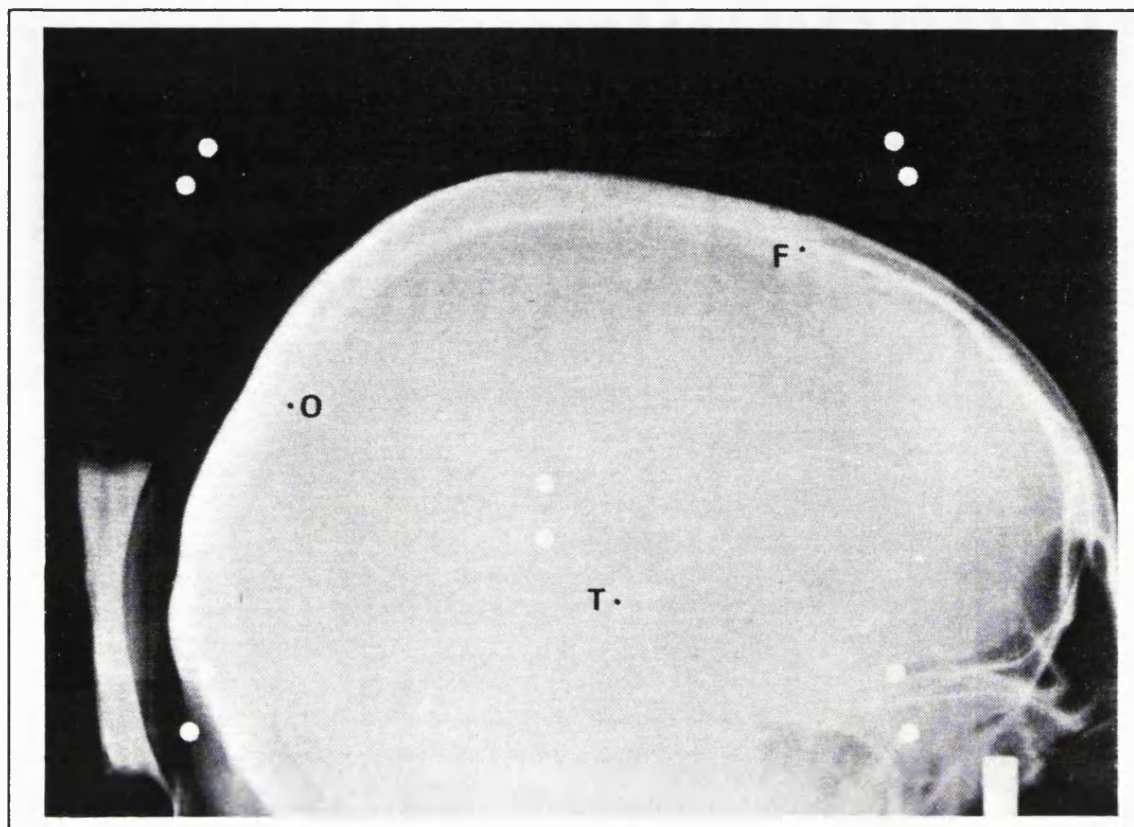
Lateral X-ray of patient fixed in Relocatable frame with attached SGV localiser (pinhole reference points indicated - F = Frontal; O = Occipital; T = Thalamic).
